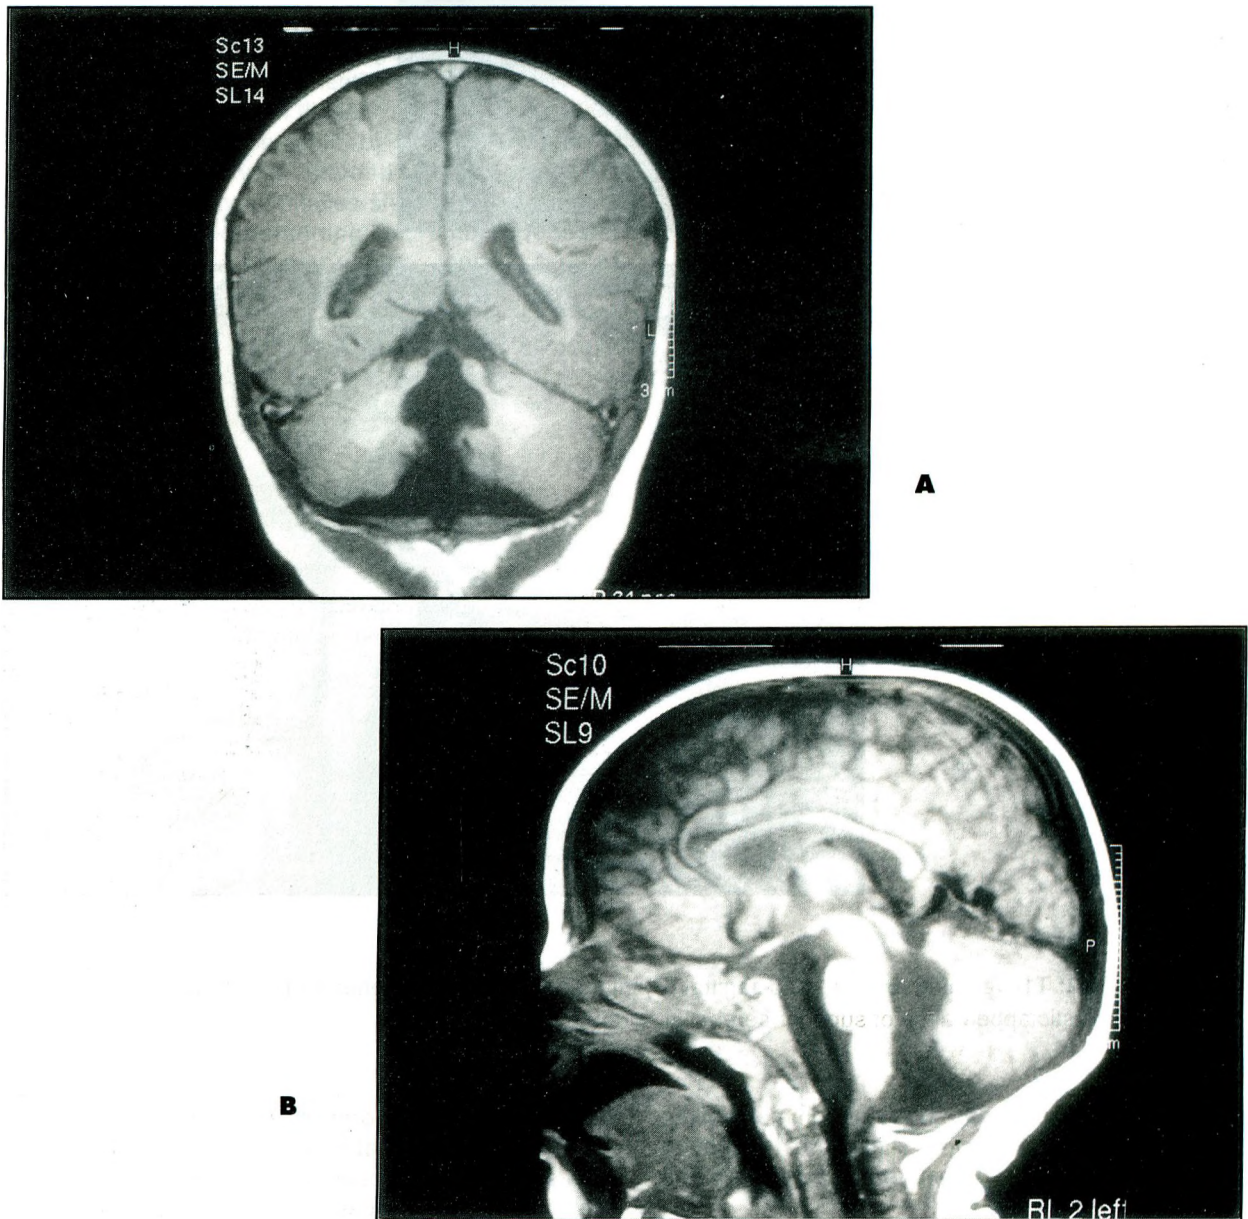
Case 1: T1-weighted coronal (A) and sagittal (B) images show agenesis of cerebellar vermis and the dysplastic appearance of superior cerebellar cortex
